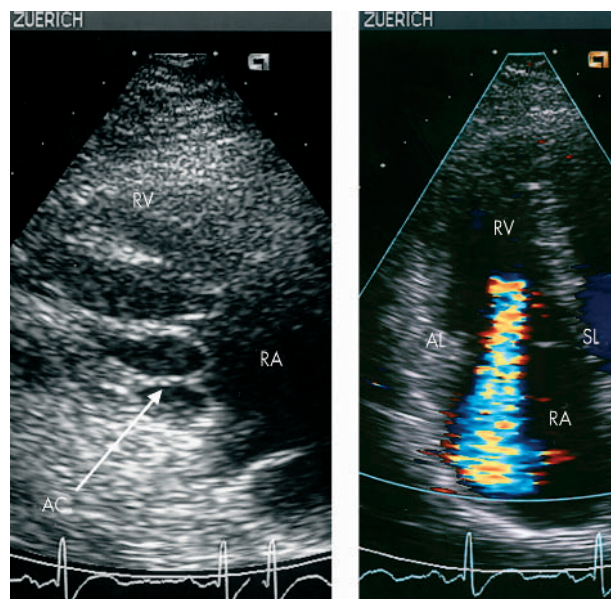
Left panel: Echocardiographic atypical parasternal long axis view of the tricuspid valve apparatus showing an aberrant chord (AC) tethering the posterior tricuspid leaflet. Right panel: Severe tricuspid regurgitation is detected in the same patient by colour Doppler in the apical four chamber view; the origin of the regurgitant jet is displaced towards the apex. AL, anterior tricuspid leaflet; AL and SL, tricuspid annulus plane; RA, right atrium; RV, right ventricle; SL, septal tricuspid leaflet.
